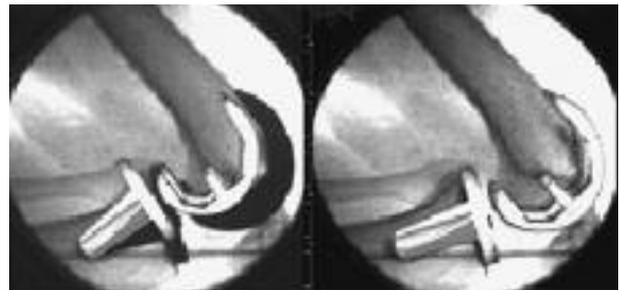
Manufacturer supplied implant surface models were projected onto the distortion corrected image and iteratively adjusted to match the x-ray silhouette of the patient's implants.
